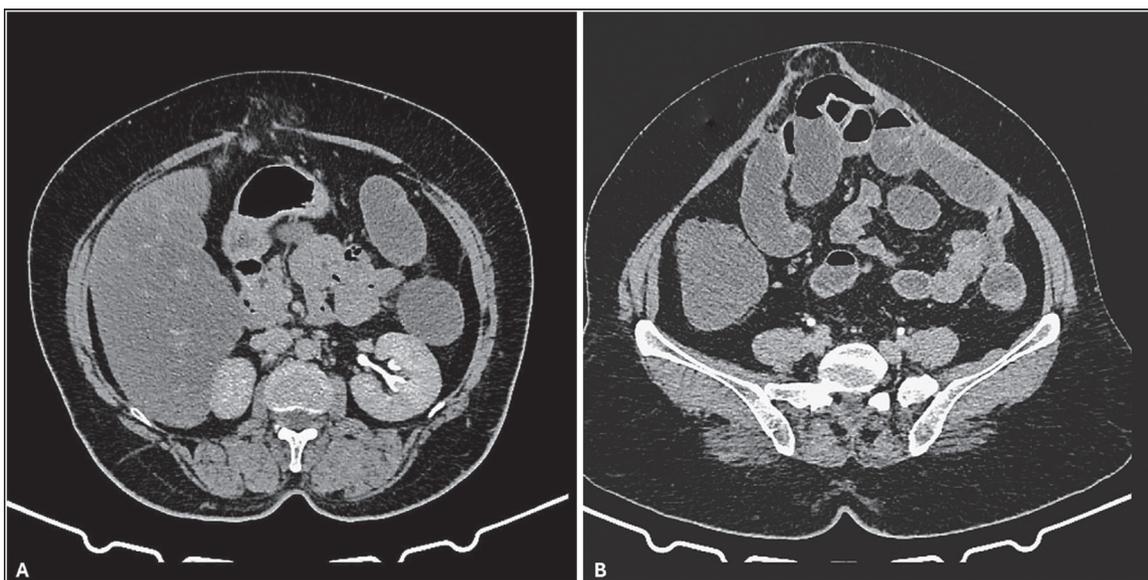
Plain CT abdomen showing hernial defects with herniation of intra-abdominal content at the supraumbilical level (A) and infraumbilical level (B). CT = computed tomography
